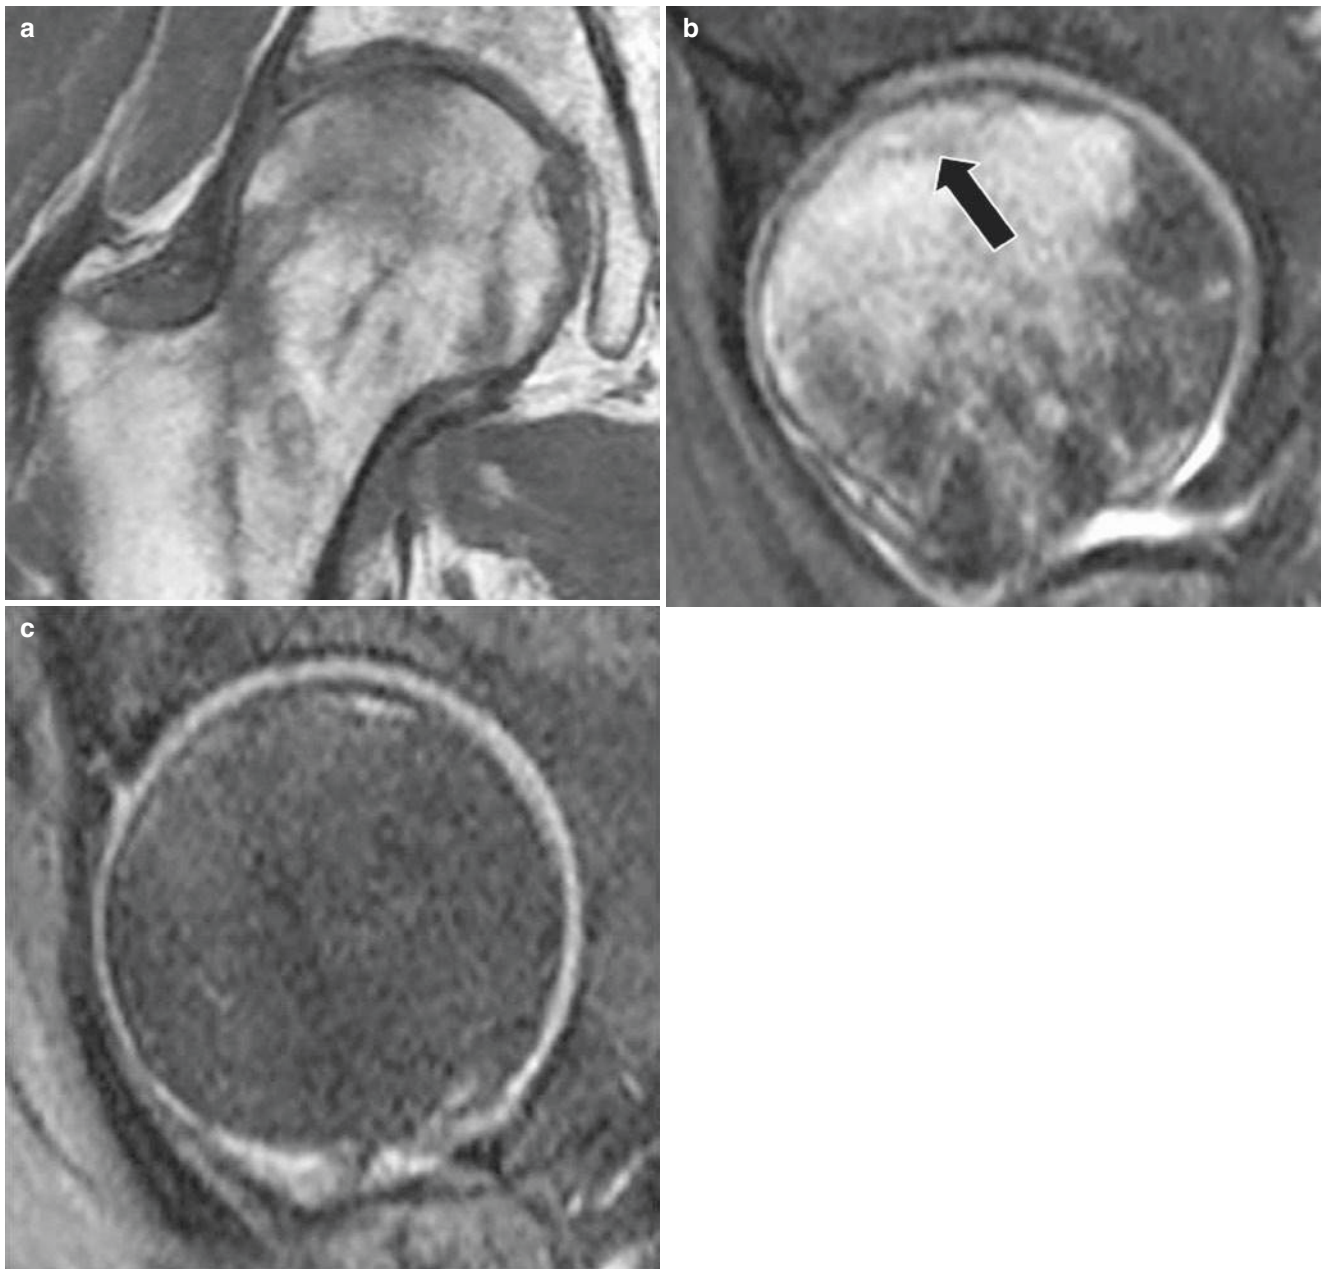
ISF of the femoral head in a 47-yo male with severe osteoporosis. (a) A coronal SE T1-weighted image of the right hip shows an ill-delimited area of marrow oedema in the femoral head. (b) On a sagittal proton-density-weighted image, the lesion shows high signal intensity.
